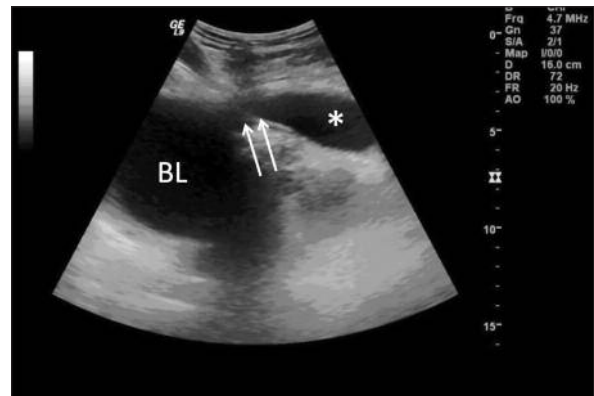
Ultrasonographic examination shows a direct fluid-filled communication (white arrows) between the herniated inguinal segment (asterisk) and the bladder (BL). At the lower right of the image is a magnified view of the herniated segment (asterisk) showing the hyperechoic bladder mucosa (white arrowheads) and the hypoechoic muscularis layer (open white arrow).
